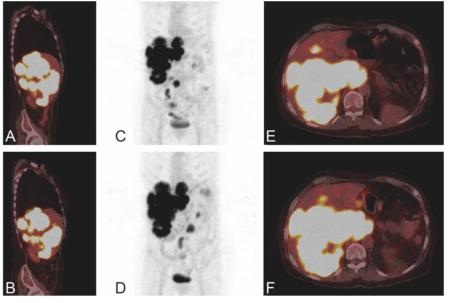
Response monitoring of liver metastases. Images of PET/CT (A, B, E, F) and the maximum intensity projection (C, D) before (A, C, E) and after (B, D, F) treatment.
